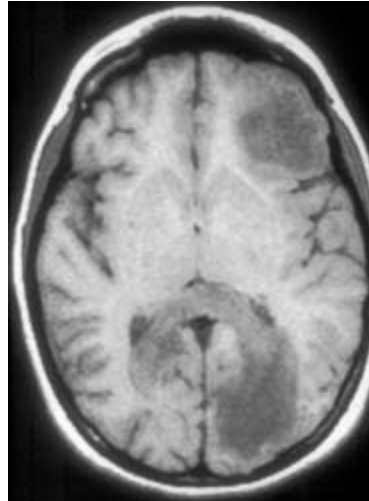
Nicknamed “black holes,” the areas of hypointensity seen on T1-weighted images are believed to indicate that MS is a disease not only of demyelination but also of axonal destruction. Image courtesy of Gordon Sze, MD.
